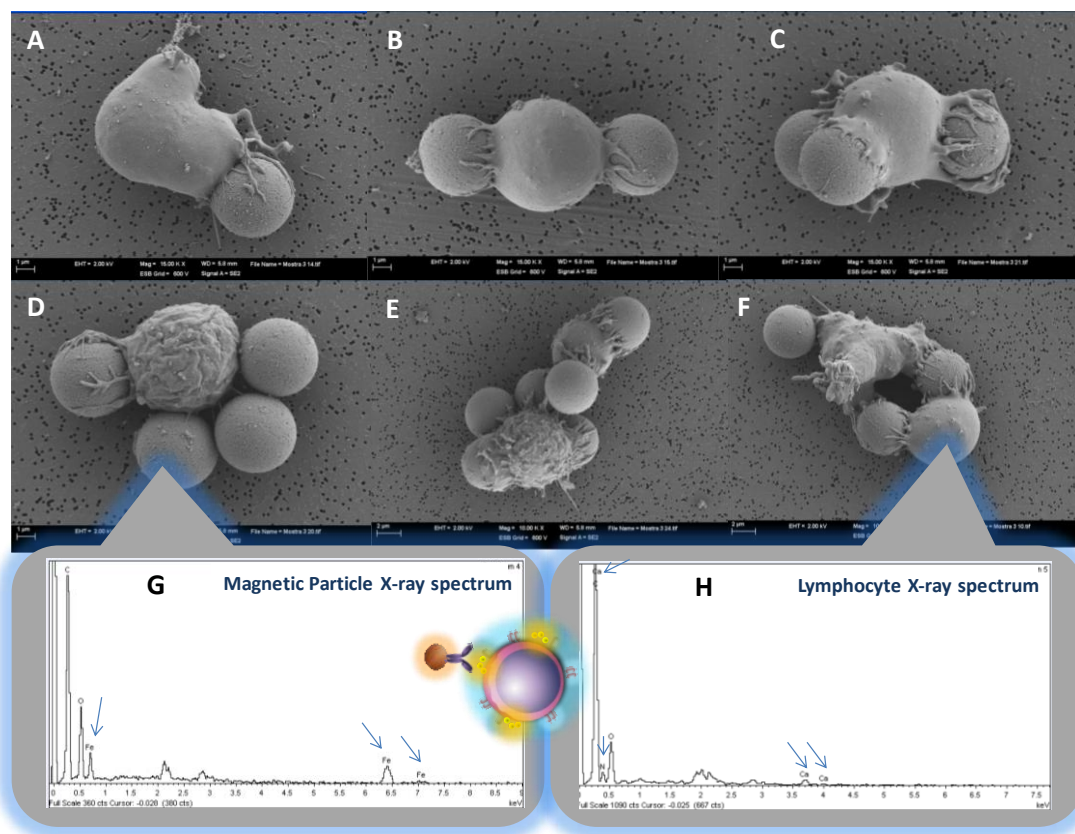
Evaluation of the CD4+ T lymphocytes immobilized on antiCD3 magnetic particles by SEM. The images show, at different resolution levels, the different patterns of lymphocyte binding to the magnetic particles, as well as the X-ray pattern. In all cases, identical acceleration voltage (15 KV) was used.
